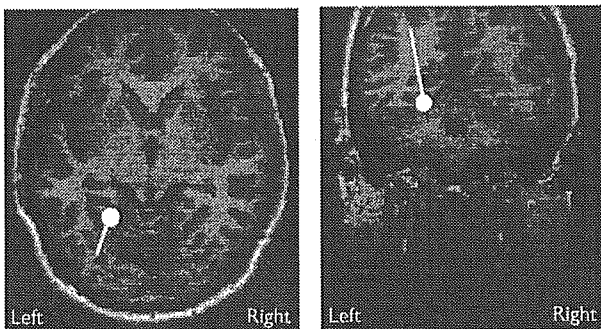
White circle with a bar indicates one representative equivalent current dipole (ECD) source estimated during the M200 time window in the kanji word condition from one subject superimposed onto horizontal and coronal MRI scans. There was no difference among the four conditions.
